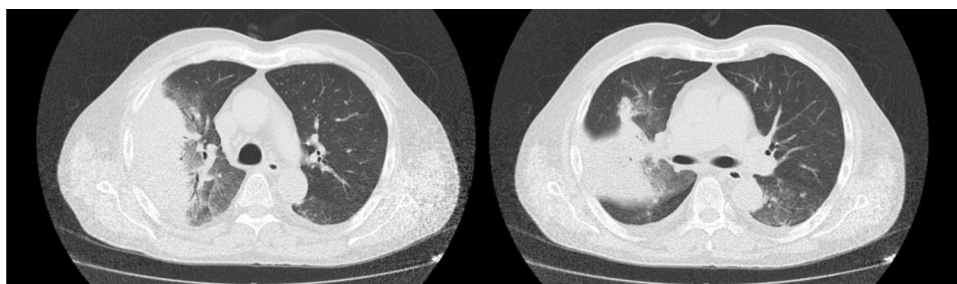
CT with evidence of extensive lung consolidation in the right upper lobe (RUL), accompanied by peripheral ground-glass opacities, and other subsegmental lung consolidations in the left lower lobe (LLL) with bronchial inflammatory signs, all suggestive of airway invasive aspergillosis.
